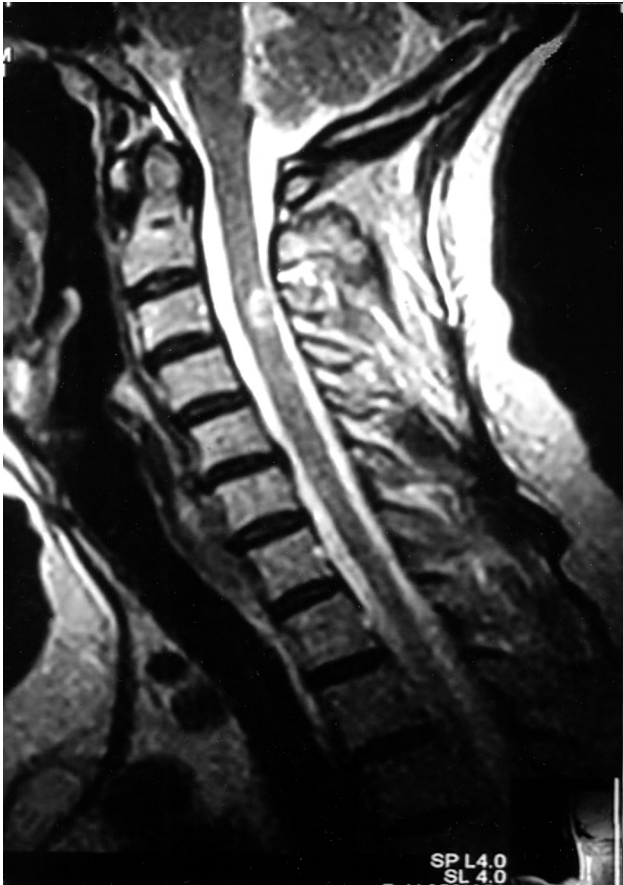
MRI of the cervical spine showing a 1.5 cm focal area of high signal intensity seen on T2 weighted images at the C3–C4 level.
